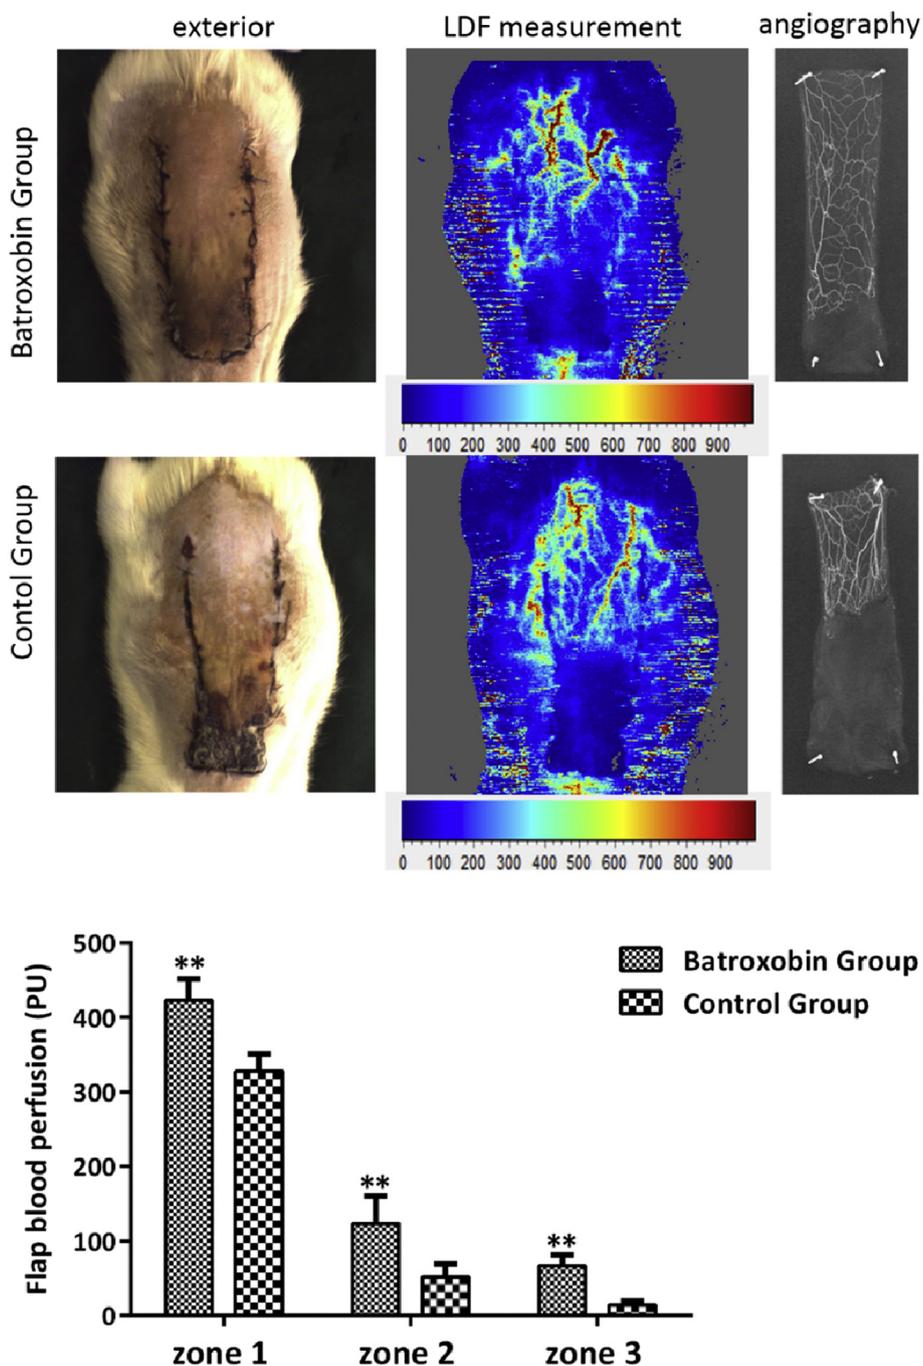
Laser Doppler flowmetry angiography and x-ray angiography of the flaps of the batroxobin group and the control group. The mean blood perfusion levels in zones 1, 2, 3 of the two groups. All values are expressed as means  $\pm$  standard deviation (SDs).  $n = 6$  per group.
